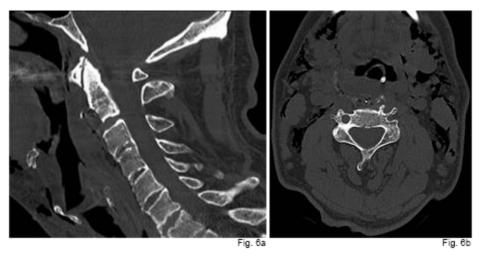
(1.5 column fitting): Immediate post-operative CT demonstrating resolution of anterior ostephytes and tracheal obstruction in a) saggital and b) transverse sections.
